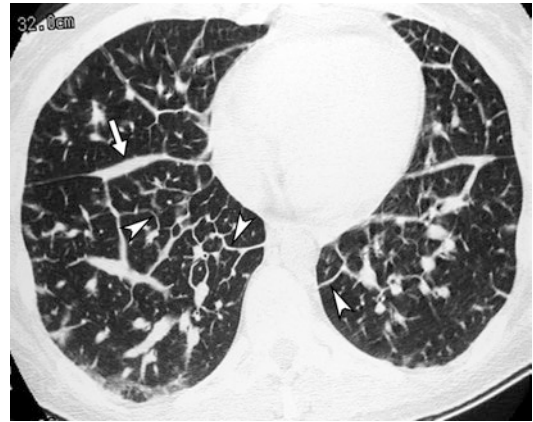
Pulmonary edema due to fluid overload in a 60-year-old woman with multiple myeloma. CT scan through lower lobes shows smooth septal thickening (arrowheads) in a gravity-dependent distribution. The right major fissure is also prominent due to subpleural edema (arrow)
